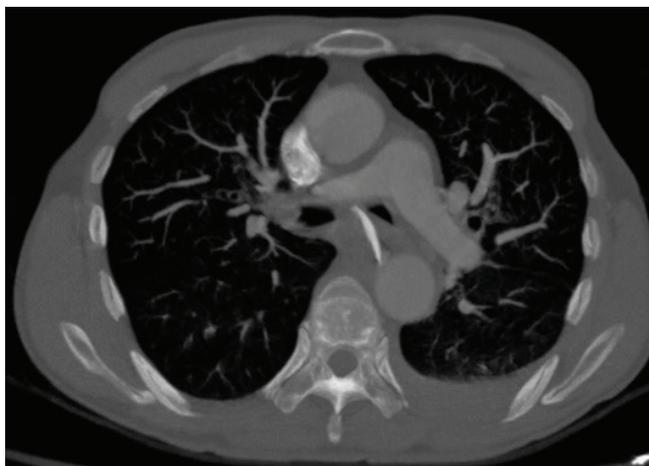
Axial maximum intensity projection computed tomography images show the extension of the foreign body from the subcarinal area to the aortic wall.
